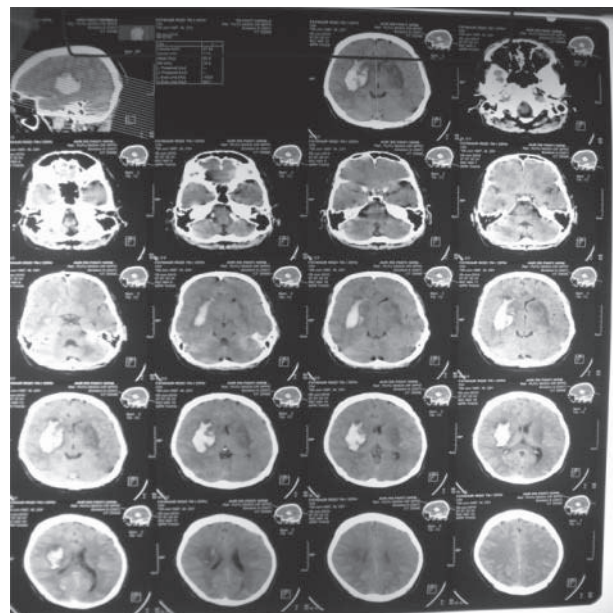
Head CT scan result of the patient showed intra-cerebral hemorrhage at right fronto temporo parietal lobe with peri-focal edema (volume 48 cc)
